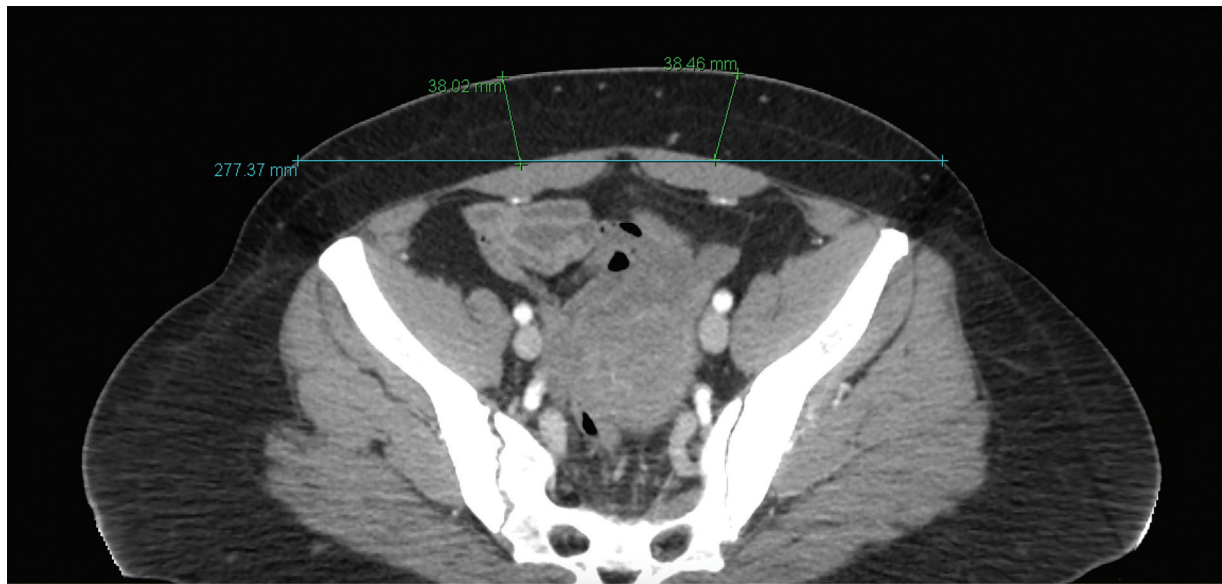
Axial computed tomography angiography demonstrating subcutaneous thickness measurements (mm) 5 cm lateral to midline in the plane of the anterior superior iliac spine (ASIS), as well as cutaneous distance between each ASIS.
